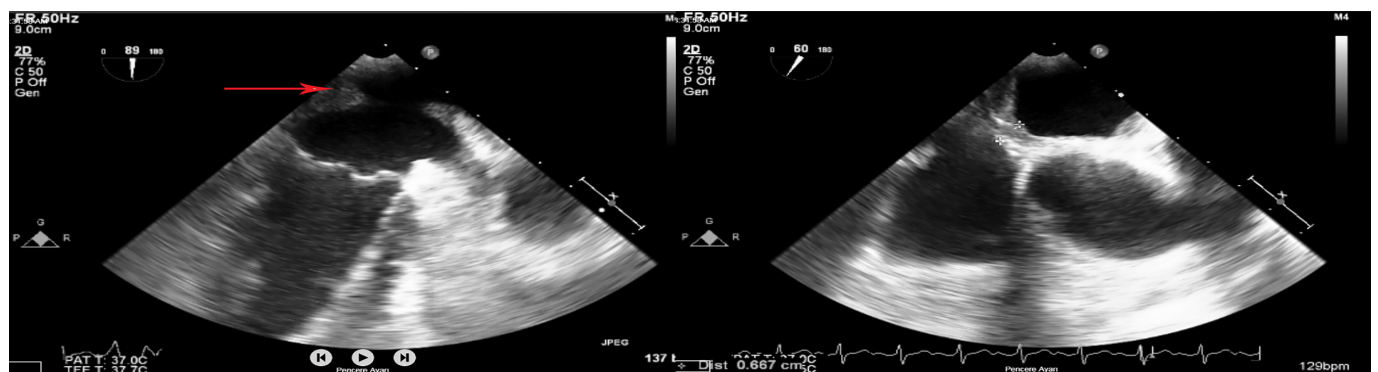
Transesophageal echocardiography images. Left panel: Two chamber view demonstrated (arrow) hypoechoic left atrial mass. Right panel: Modified bi-atrial view demonstrated increased thickness and heterogenous appearance of interatrial septum.
